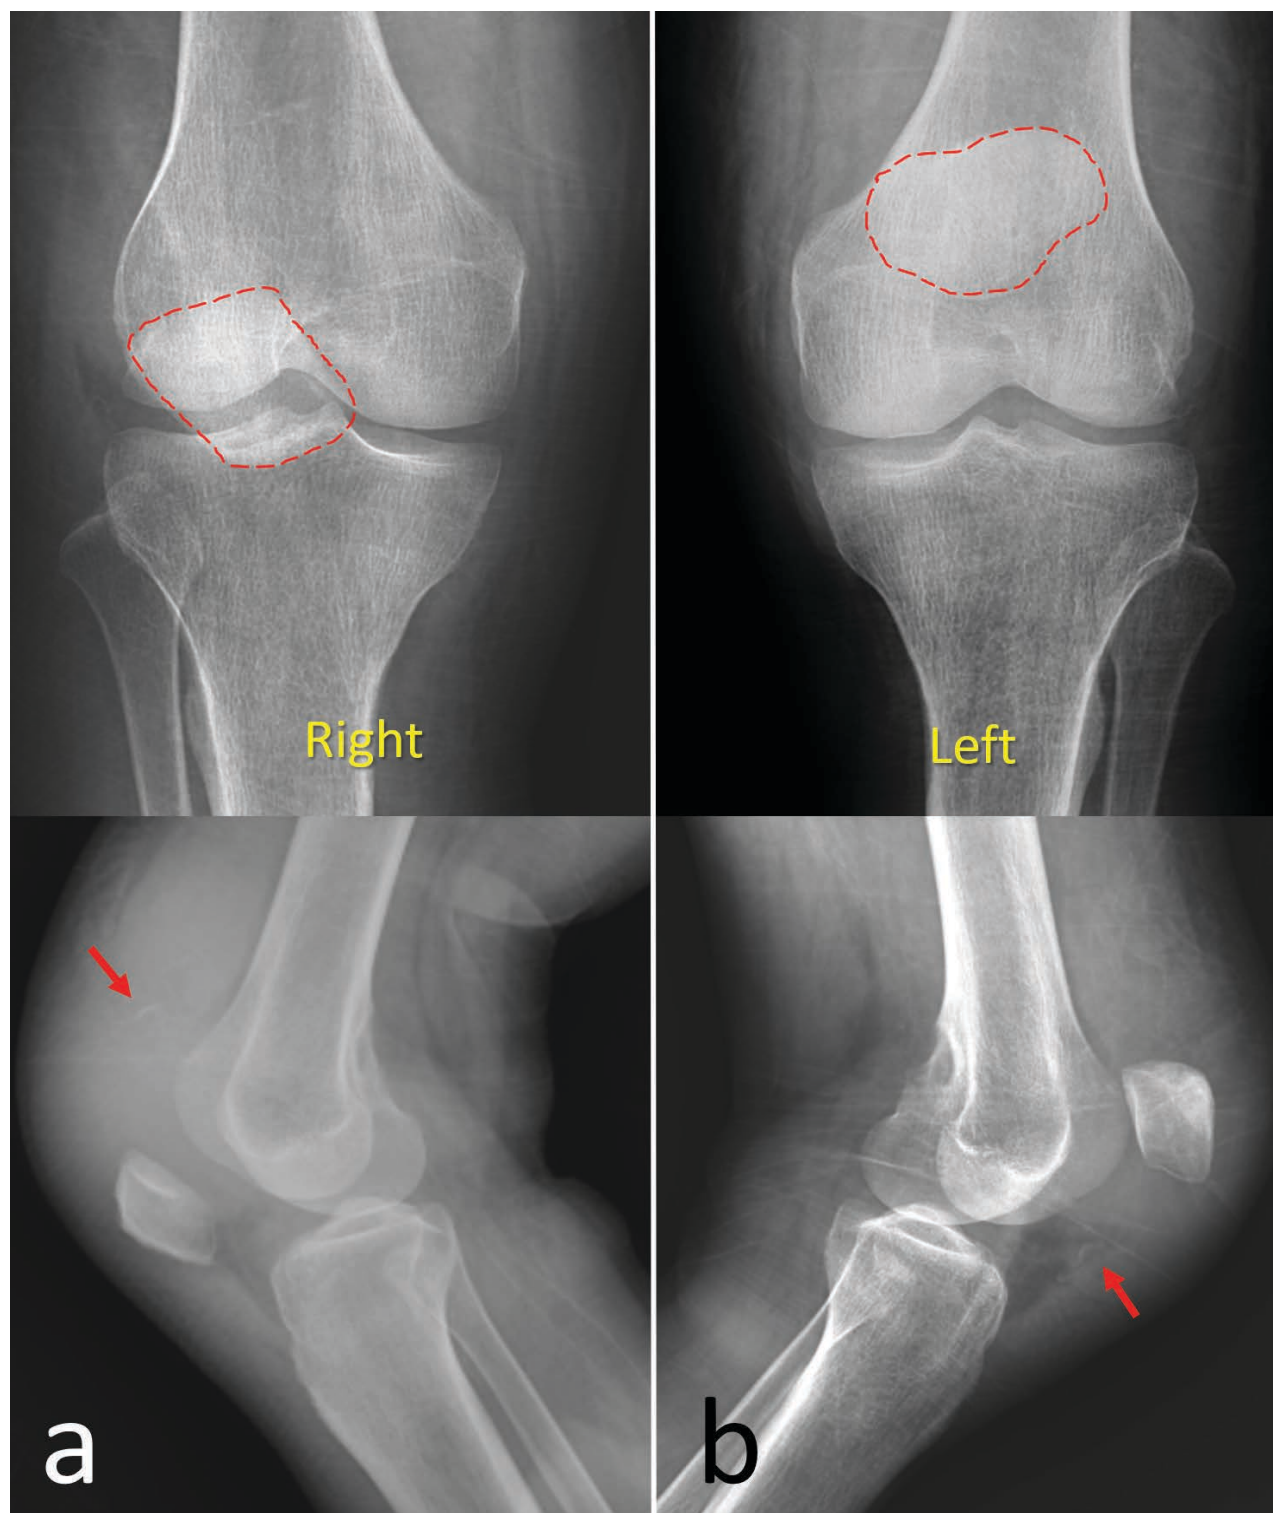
Anteroposterior and lateral direct radiographs of right (a) and left (b) knees. Patella baja at right knee (red dotted circle), and patella alta at left knee is observed. On lateral views, small avulsion fractures are observed (red arrows).
